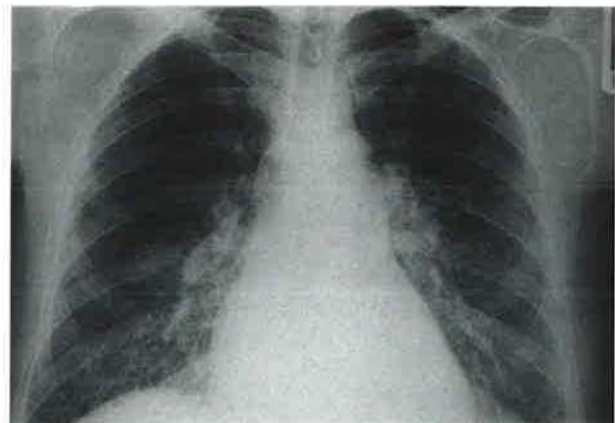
The chest X-ray shows reticulonodular shadowing in the lower zones and septal lines seen most clearly at the right base. There are prominent pulmonary vessels.
